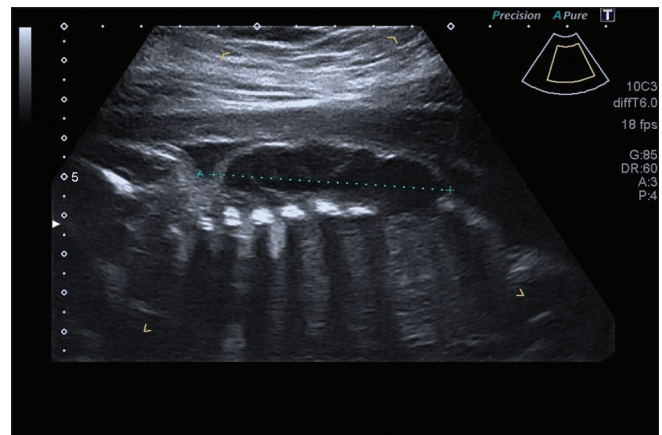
Twenty-one-week ultrasound: Sagittal plane of fetal thorax showing a multilocular tumefaction
